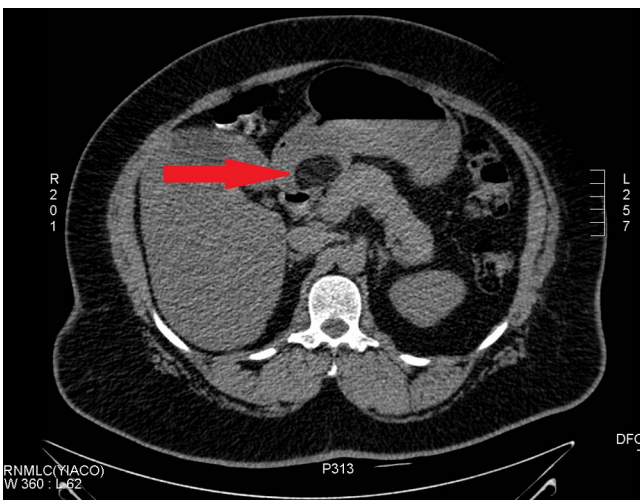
Computed tomography scan of the abdomen showing a suspicious oval 3.5 × 3 cm mass in the antrum of the stomach.
